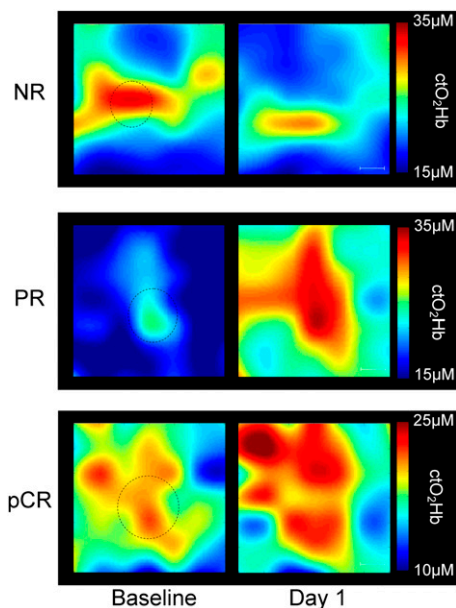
ctO_2Hb maps from three different subjects at baseline and day 1 after the start of neoadjuvant chemotherapy. Each map shows a 6×6 -cm measurement area that includes the tumor and a surrounding normal margin. (Scale bar: 1 cm.) The circles represent the location and approximate anatomic size of the tumors determined by ultrasound. (Top) An example of a 17-mm tumor that did not respond to chemotherapy. Mean tumor ctO_2Hb dropped 21.6% at day 1, and spatial extent decreased by 54.3%. (Middle) An example of a partial response. Tumor was 20 mm before chemotherapy. Mean tumor ctO_2Hb increased 53.1% at day 1, and spatial extent increased by 142.1%. (Bottom) An example of a pathologic complete response. Tumor was 30 mm before chemotherapy. Mean tumor ctO_2Hb increased 5.6% at day 1, and spatial extent increased by 4.5%.
